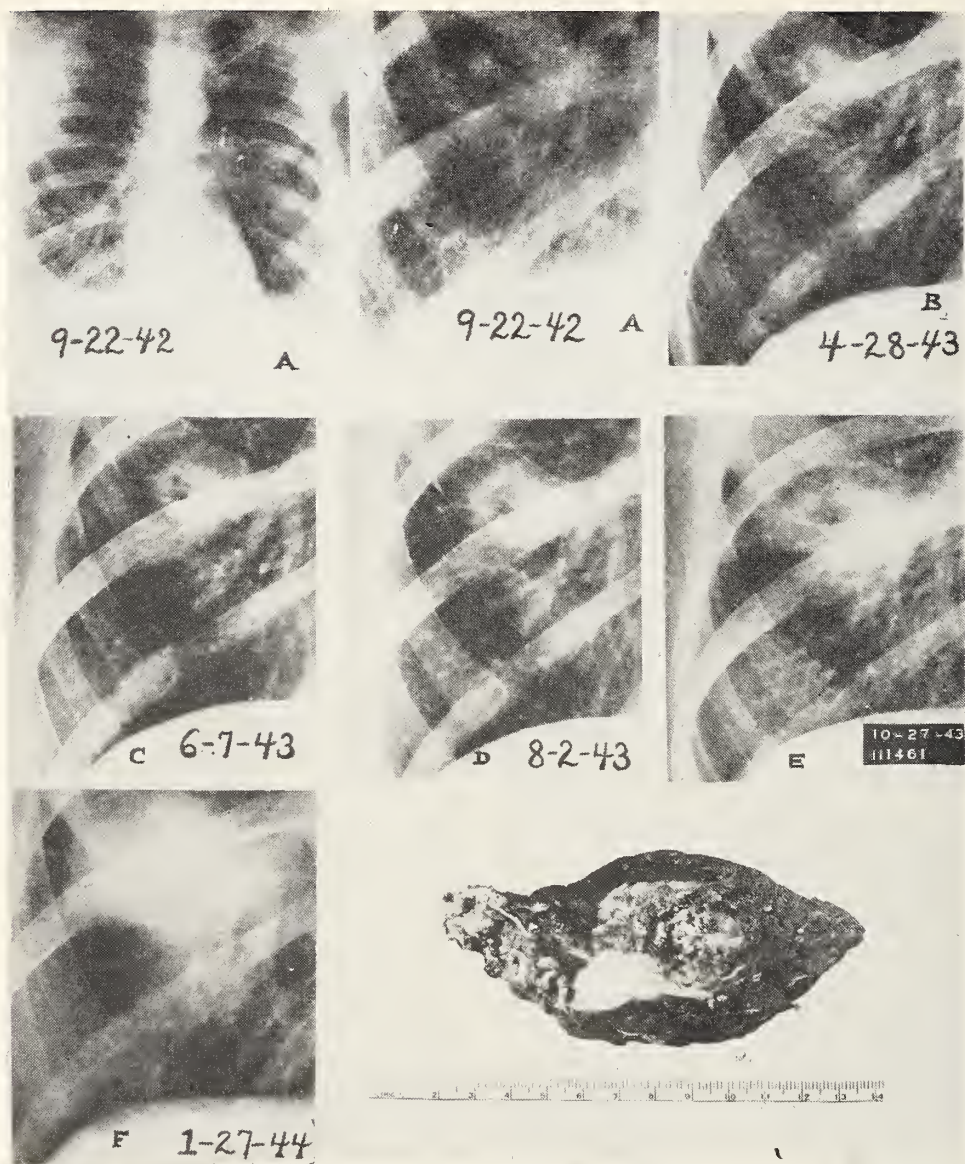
(Case No. 10). X-ray appearance over a sixteen month period produced by a squamous cell type of primary carcinoma of the right lung. Note gradual increase in size and cavity formation. Patient was asymptomatic when lesion was removed.
